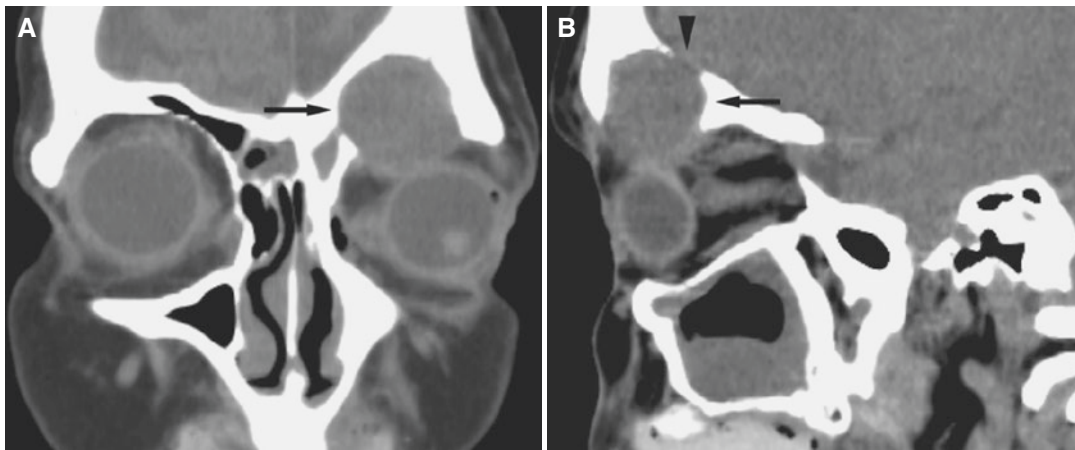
Frontal sinus mucocoele; 52-year-old female with headache and diplopia. (A) Coronal CT image shows well-defined soft-tissue mass with no air in the left frontal sinus with bone expansion (*arrow*), displacing globe down and laterally. (B) Sagittal CT image shows
